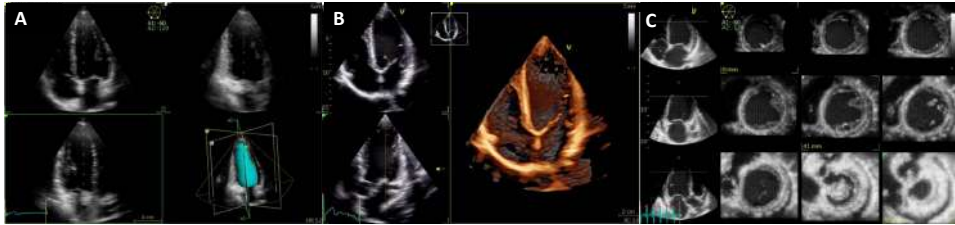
Three-dimensional transthoracic echocardiography of the left ventricle. (A) Triplane view of the LV allows simultaneous and single-beat acquisition of the three apical views. By tracing the endocardial borders, the LV volume is obtained (surface rendering, bottom right). (B) Real-time single-beat 3D acquisition of the LV from the apical window. Volume renders allow for offline reconstructions. (C) Tomographic multislice obtained from a multiple-beat apical view. Wall motion abnormalities can be assessed with this technique.
